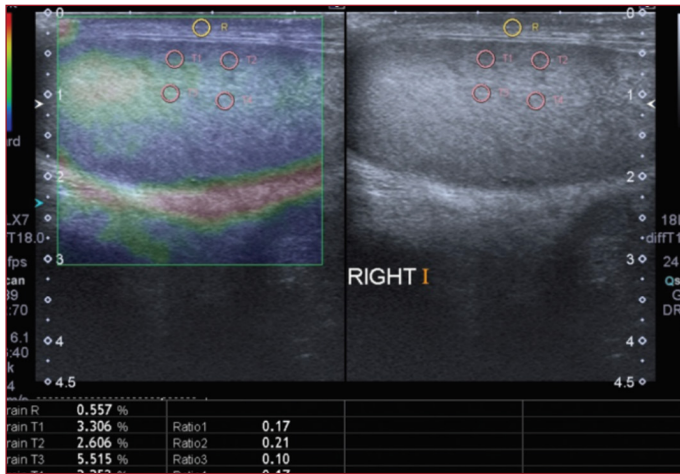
B mode and ultrasound elastography image of the right testis. The upper ROI is in the subcutaneous tissue and the lower four ROIs are in the subcapsular and intraparenchymal area.
